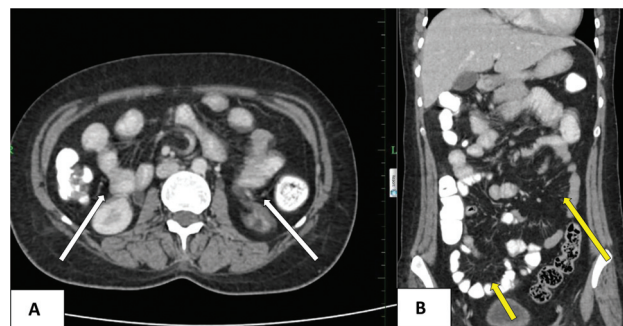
Follow-up contrast-enhanced computed tomography (CECT) of the abdomen performed 1 week after commencement of therapy. (A) Axial section showing complete resolution of bowel wall thickening (arrows). (B) Coronal section showing remission of mesenteric engorgement (arrows) and ascites.
